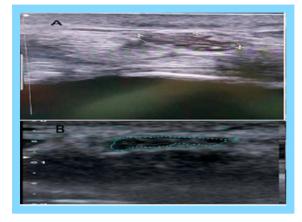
Ultrasound examination of median nerve diameter in a 39-yearold woman diagnosed as having carpal tunnel syndrome (the dotted area). (a) Preoperative. (b) At 3 months.
